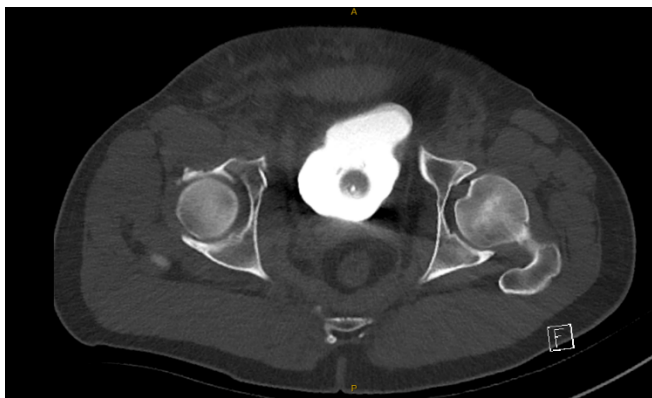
CT cystogram demonstrating herniation through pubic symphysis.
